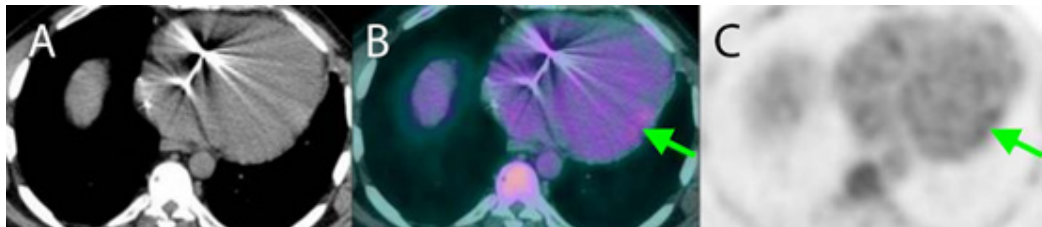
^{18}F -FDG PET-CT in a patient with chagasic cardiomyopathy and pacemaker (A, axial CT; B, axial PET-CT; C, axial PET). Mild uptake was observed in the basal anterolateral segment. This finding could potentially indicate mild ventricular inflammation.
